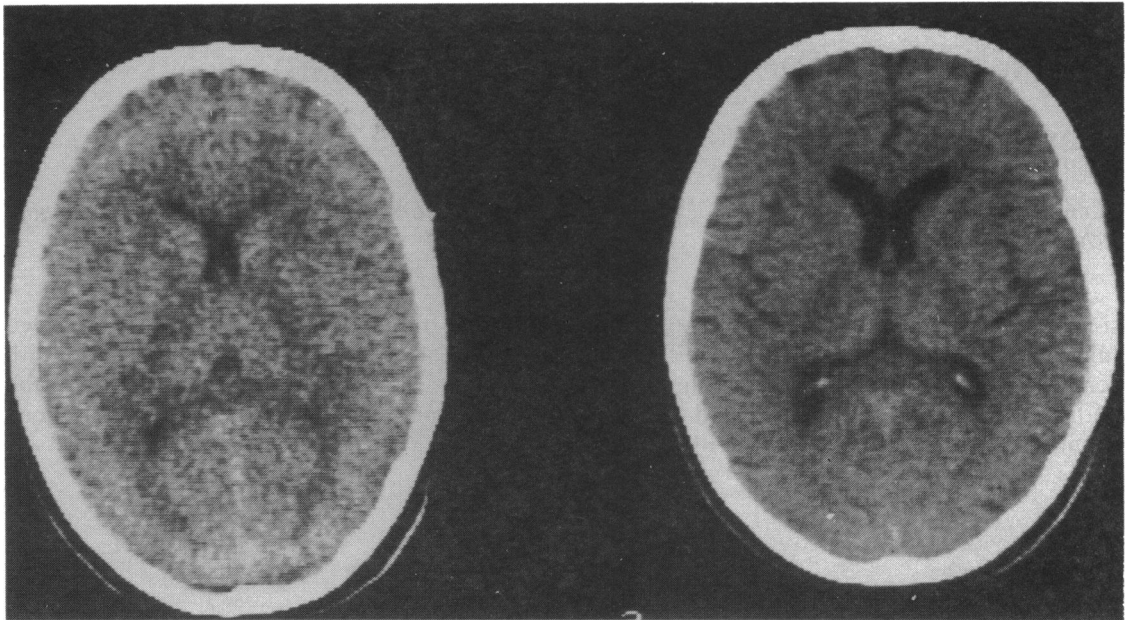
A CT scan 18 hours after admission to hospital (left) shows an absence of sulci and compression of the lateral ventricles, indicating cerebral oedema. By day 14 the cerebral oedema had resolved (right).
